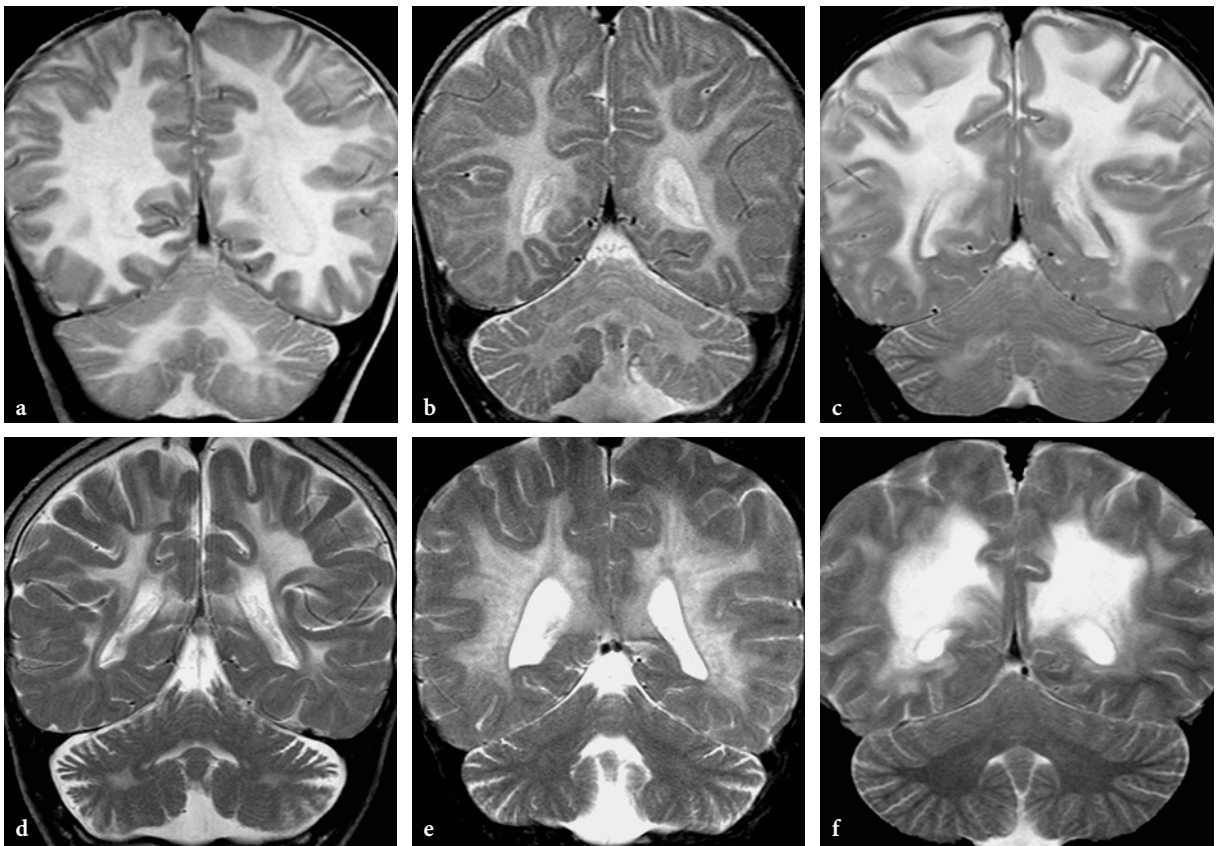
Patterns of involvement of cerebellar white matter on coronal T2-weighted fast spin-echo images in various leukodystrophies. a 10-month-old male patient with Canavan disease. The central and the peripheral white matter structures are equally involved in the cerebellum. No cerebellar atrophy is seen. b 11-month-old male patient with globoid cell leukodystrophy (Krabbe disease). Diffuse involvement of the cerebellar white matter, somewhat less prominent than in Canavan disease and associated with atrophy. c 7-year-old female patient with van der Knaap disease. Moderate signal abnormalities within the deep cerebellar white matter structures, including the hili of the dentate nuclei. The subcortical white matter is spared. No cerebellar atrophy is seen. d 10-year-old male patient in the advanced stage of metachromatic leukodystrophy. The pattern of the cerebellar white matter involvement is quite similar to that seen in van der Knaap disease, except for the associated atrophy, which is clearly shown in this case. e 2-year-old male patient with metachromatic leukodystrophy (saposin B deficient). In this stage of the disease, only very subtle central white matter signal changes are suggested (sometimes better appreciated on FLAIR images, not shown here). Mild atrophy is, however, already conspicuous. f 12-year-old male patient with X-linked adrenoleukodystrophy (same patient as Fig. 13.8d). No signal abnormality or atrophy is seen at the level of the cerebellum
